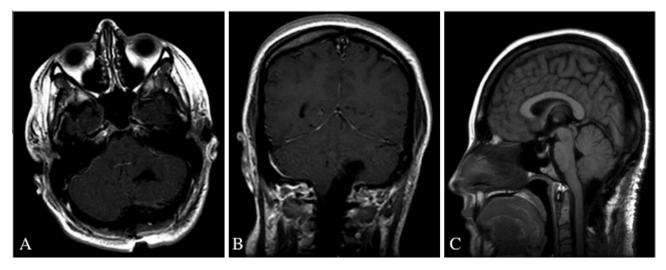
(A) Axial, (B) coronal and (C) sagittal gadolinium-enhanced T1-weighted MRI demonstrating gross total resection of the pilomyxoid astrocytoma.
